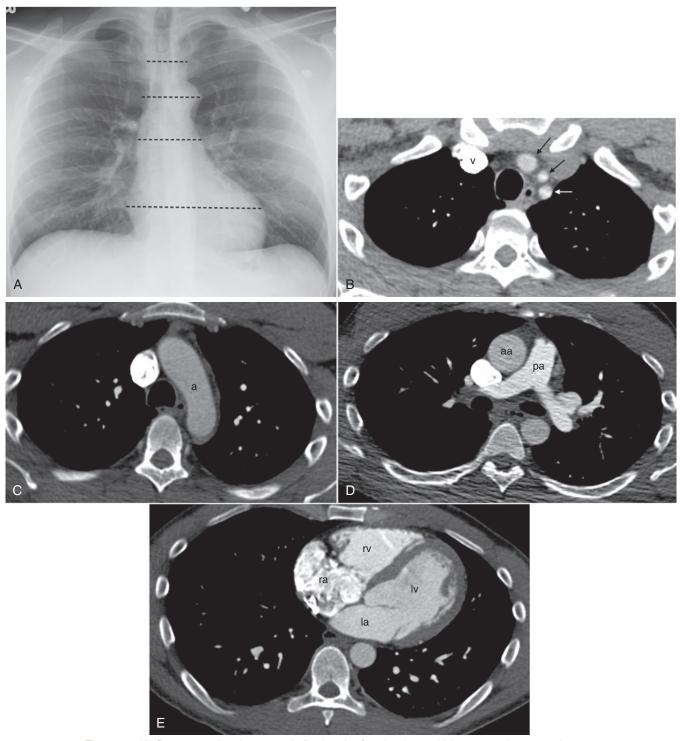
(A) Posteroanterior chest x-ray indicating the four levels at which computed tomography scan slices (B) to (E) were obtained. (B) The most superior image is at the level of the great vessels. Contrast material fills the right brachiocephalic vein (v) and the three arch vessels, the right brachiocephalic, left common carotid, and left subclavian arteries. (C) At this level, the arch of the aorta (a) lies on the left side of the airway. The esophagus is seen in front of the vertebral body behind the airway. The opacified superior vena cava lies to the right of the arch anteriorly. (D) At the level of the pulmonary artery (pa) bifurcation, the right pulmonary artery crosses the mediastinum anterior to the right main bronchus. The vena cava lies to the right of the ascending aorta (aa). The descending aorta is seen next to the vertebral body. (E) At the level of the heart, contrast material is seen filling the right atrium (ra) and crossing the atrioventricular (tricuspid) valve into the right ventricle (rv). The thick, muscular left ventricular (lv) wall is visualized as it contracts. The left atrium (la) is seen anterior to the esophagus.
